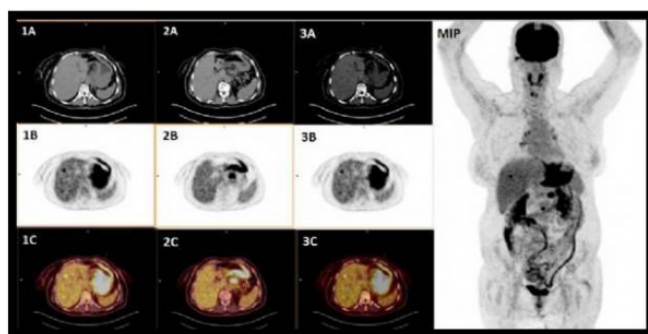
55 year-old female fundus localised signet ring cell gastric carcinoma (SUVmax=30.23) (1A:PET,1B:CT,1C:PET-CT fusion), locoregional lymph node metastasis (SUVmax=40.78) (2A:PET,2B:CT,2C:PET-CT fusion), liver metastasis (SUVmax=35.79) (3A:PET,3B:CT,3C:PET-CT fusion)
